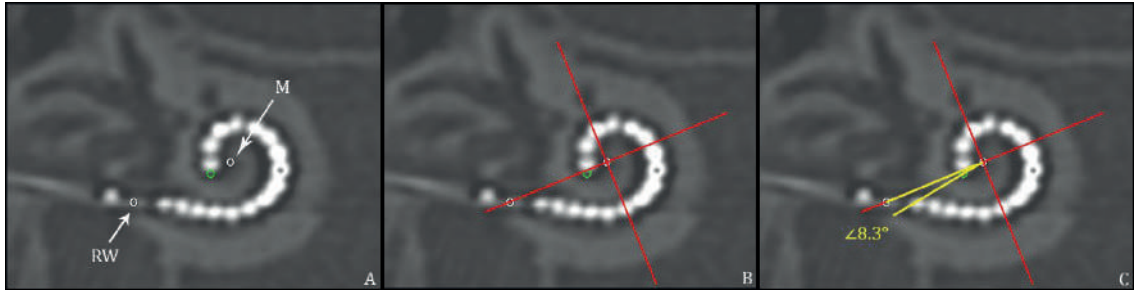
Method for angular insertion depth measurement on CT-scan of an implanted electrode array with 16 electrode contacts. Within a 3 dimensional cylindrical coordinate system all spatial information of the cochlea and an implant is measurable. By consensus this cochlear framework is defined by a plane of rotation through the basal turn of the cochlea and a z-axis through the modiolus. This can be applied on CT of the temporal bone by making a multiplanar reconstruction along the basal turn of the cochlea (Fig.1A, Fig.1B, Fig.1C), and placing the z-axis through the centre of the cochlea; the modiolus (M). Figure 1A: An angular measurement of the insertion depth can then be made by indicating the centre of the round window (RW) and the tip of the electrode array (green circle). Figure 1B: A 0° reference line between the modiolus (M) and the middle of the round window (RW), and a perpendicular line from the modiolus on the 0° reference line is drawn (red cross). Figure 1C: An angle is drawn (in yellow) from the modiolus over the 0° reference line, and through the most apical point the tip of the electrode array (green circle). In this example the angular insertion depth of the most apical electrode contact is 368.3°; the sum of four quadrants equal to 360° plus the measured yellow angle equal to 8.3°.
